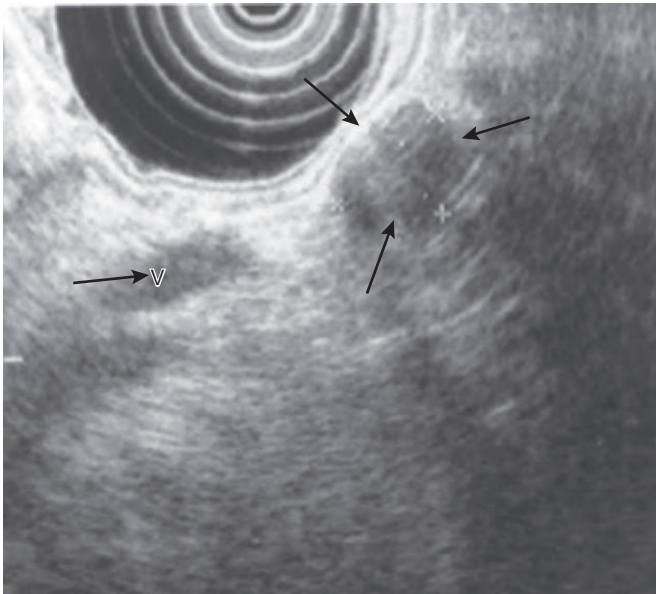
Endoscopic ultrasound with the transducer in the stomach. It demonstrates a small hypodense mass (insulinoma) within the tail of the pancreas (arrows). The relationship to the splenic vein (V) is also seen.
